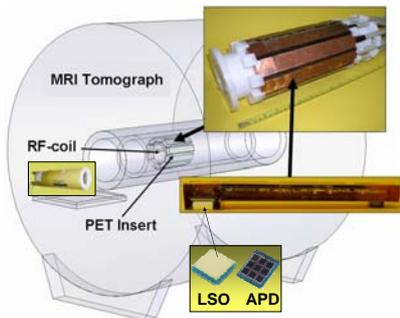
Developed PET/MRI System of Tübingen. The PET insert is composed of ten block detectors using a 12x12 LSO matrix which is read out with a 3x3 APD array. APD-PET signals are lead outside the 5 Gauss fringe line and processed to listmode data.
